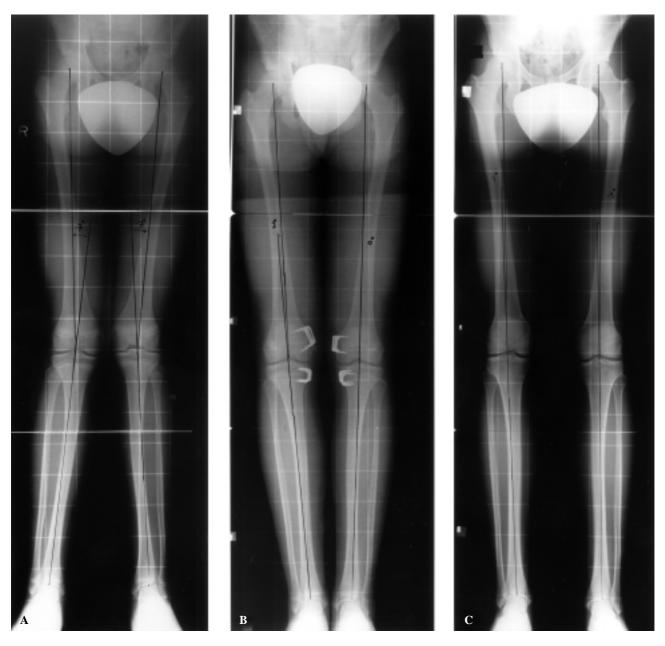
A) radiograph showing frontal full-leg images at the time of surgery; B) after correction achieved by stapling; C) at bony maturity and after removal of the staples.
